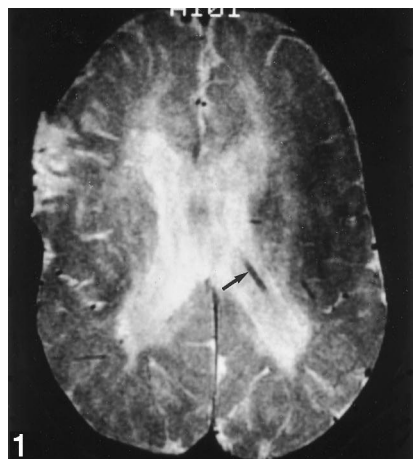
Case 1: age 13 years. Axial T2-weighted MR image (2000/80/2) shows dilated lateral ventricles, a shunt within the left lateral ventricle (arrow), and abnormally increased signal in the white matter surrounding both lateral ventricles.
